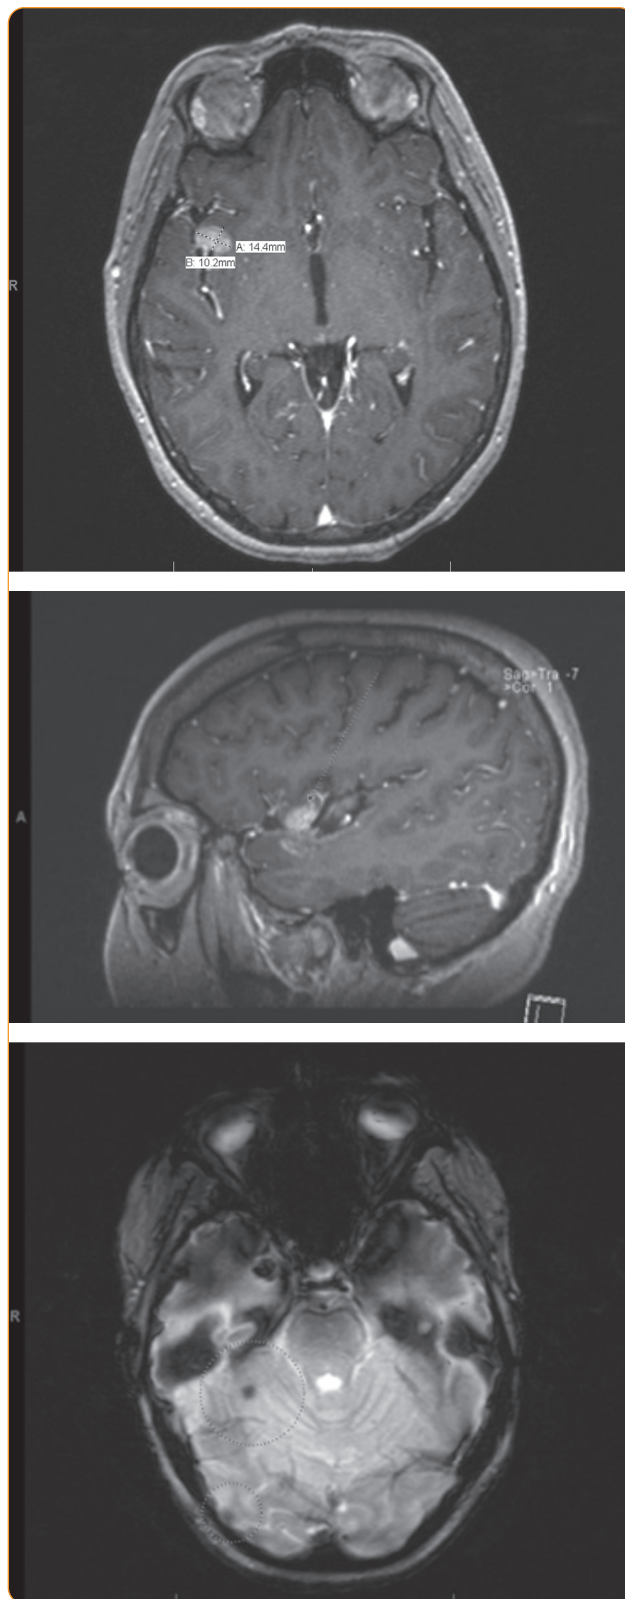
MRI brain with and without contrast showing significant progression of extensive leptomeningeal carcinomatosis (10/6/2017).
